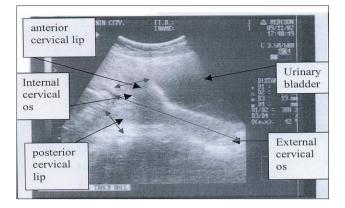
Ultrasonogram showing cervix (second trimester preganancy). Internal cervical os was closed, cervix length was 93mm, anterior lip of uterine internal cervical os diameter was 24mm and the lower lip of uterine internal cervical os diameter was 19mm.
